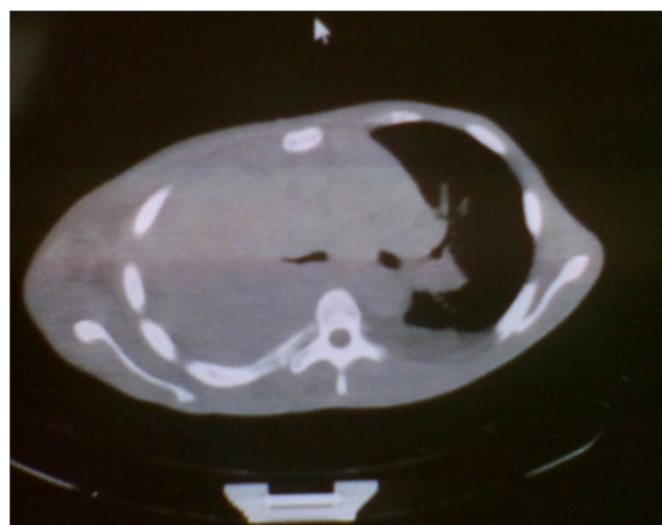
Simple CT Scan that show lung asymmetry for hipodensity area of lung with tumoral aspect that impresses to obliterate for infiltration the bronchus of the right inferior lobe.
